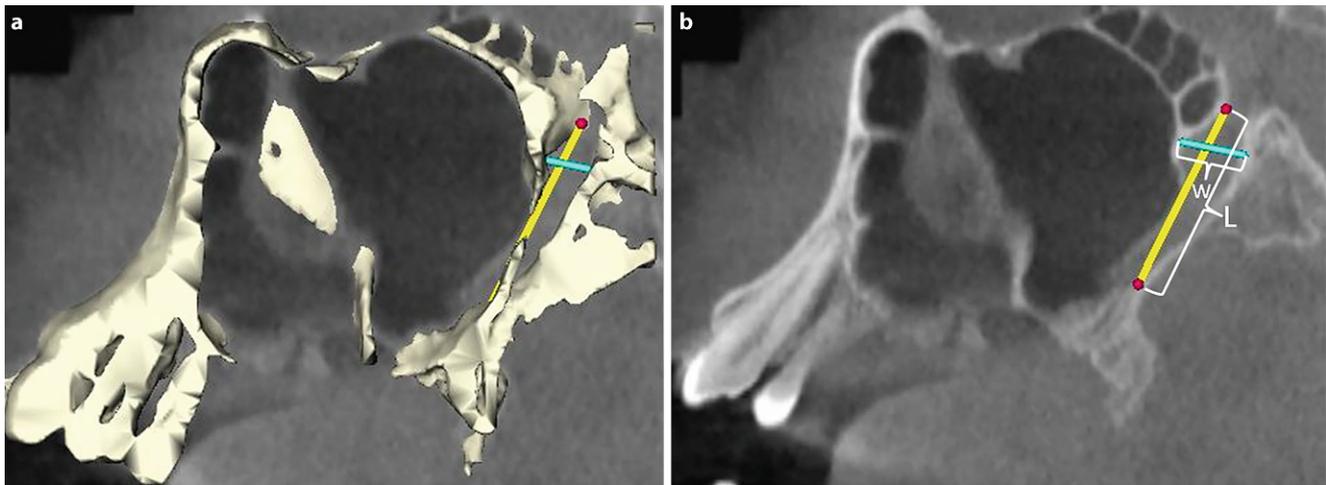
a Three-dimensional (3D) representation and sagittal slice of the pterygomaxillary fissure (PMF) region using Maxilim software. Superimposed version of the 3D model matrix on the sagittal x-ray slice. b Measurement of PMF length and width from the 3D reconstruction. Sagittal x-ray slice only. *L* length of the PMF, *W* width of the PMF
